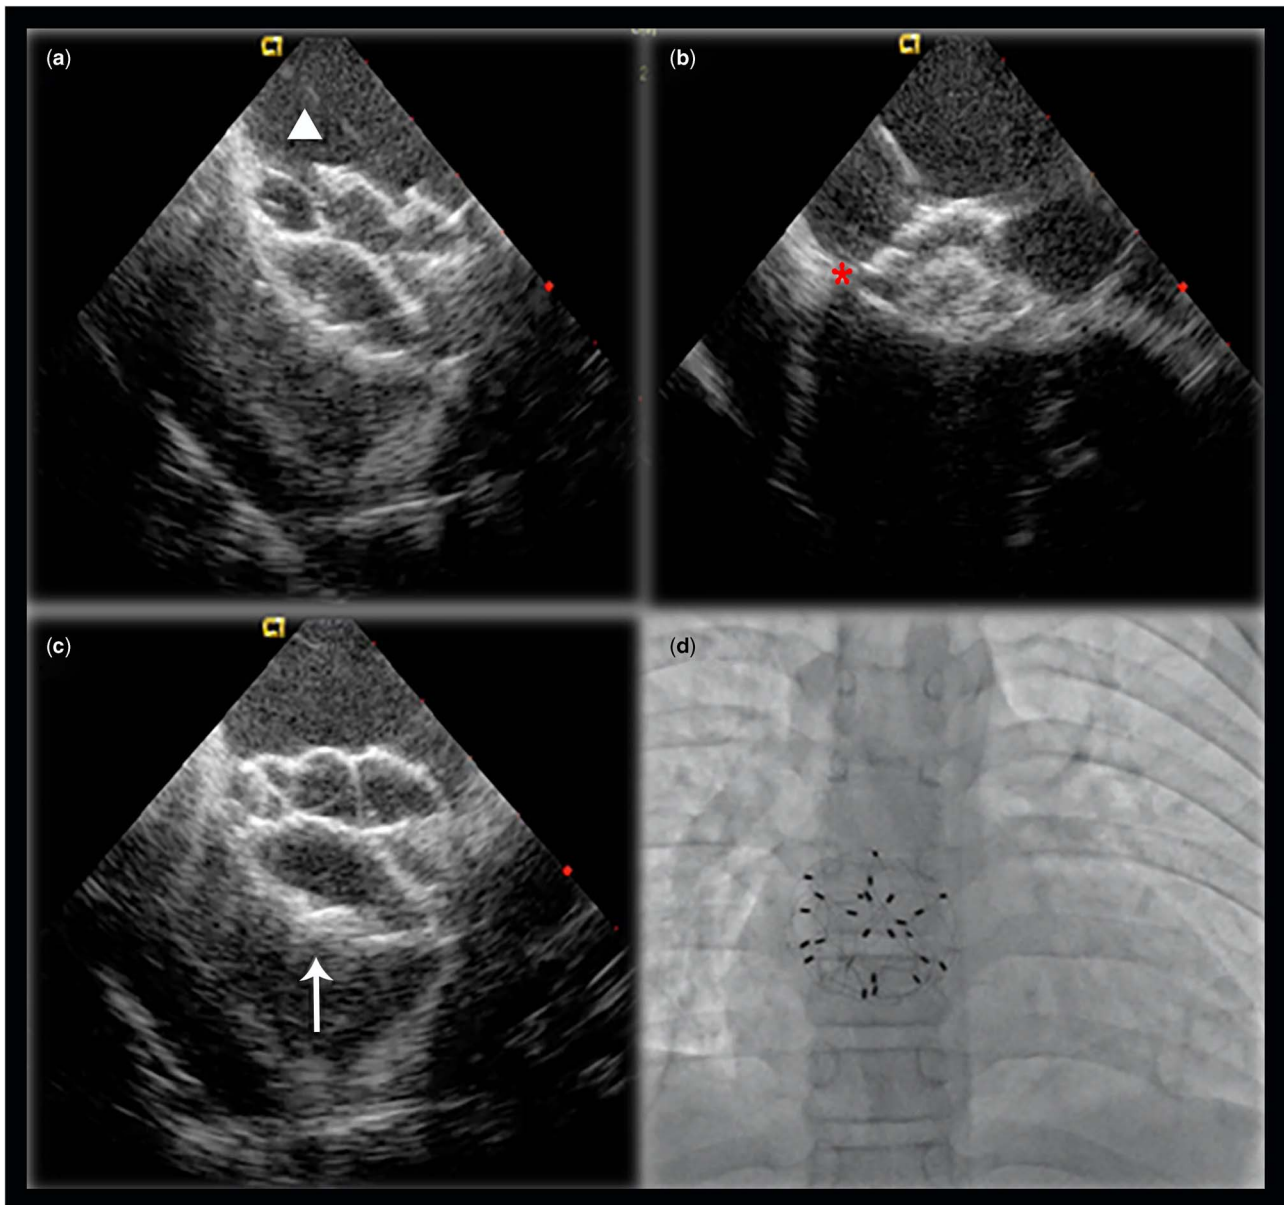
Final sequence once the Cardia Ultrasept II™ device has been placed. (a) Intracardiac echocardiogram. The correct placement of the device that is still being held by the cable (tip of the arrow). (b) Minnesota Manoeuvre where the correct position of both disks around the posteroinferior border can be observed (asterisk). (c) Intracardiac Echocardiogram. The device after being released (arrow). (d) Final position of the device seen by fluoroscopy.
